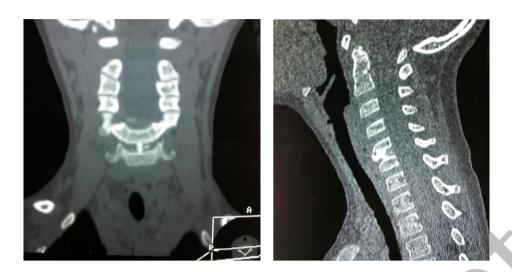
Radiography of cervical spine; calcified lesion between C4 and C5 vertebrae
